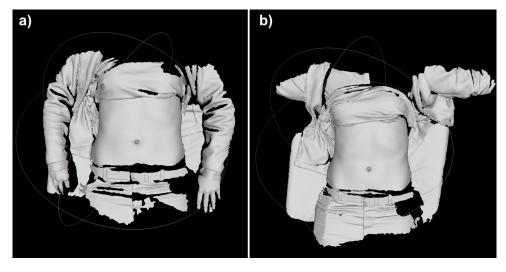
Volunteer in the position of the patient during the CTA scan (a) and in the position of the patient during surgery.
